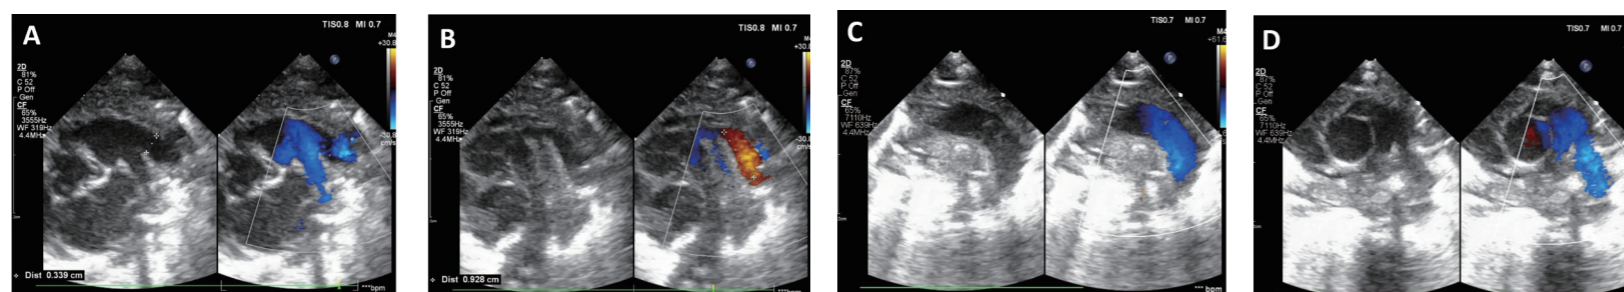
Transthoracic echocardiography of the patent ductus arteriosus (PDA) before and after Amplatzer Piccolo occluder deployment. (A) PDA diameter. (B) PDA length. (C) No left pulmonary artery stenosis after APO deployment. (D) No coarctation of the aorta after Amplatzer Piccolo Occluder deployment.
